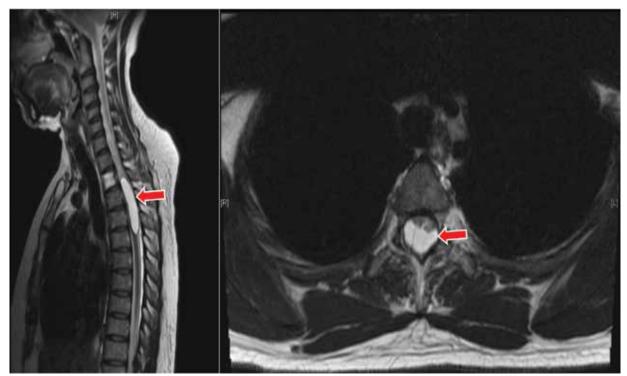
Intradural extramedullary encapsulated lesion extending rostrally from the T2-T5 level. Left. Sagittal T2-weighted MRI showing a large hyperintense intradural mass (red arrow) rising from T2-T5. Right. Coronal T2-weighted MRI showing an intradural extramedullary hyperintense mass (red arrow) at the level of T2.
